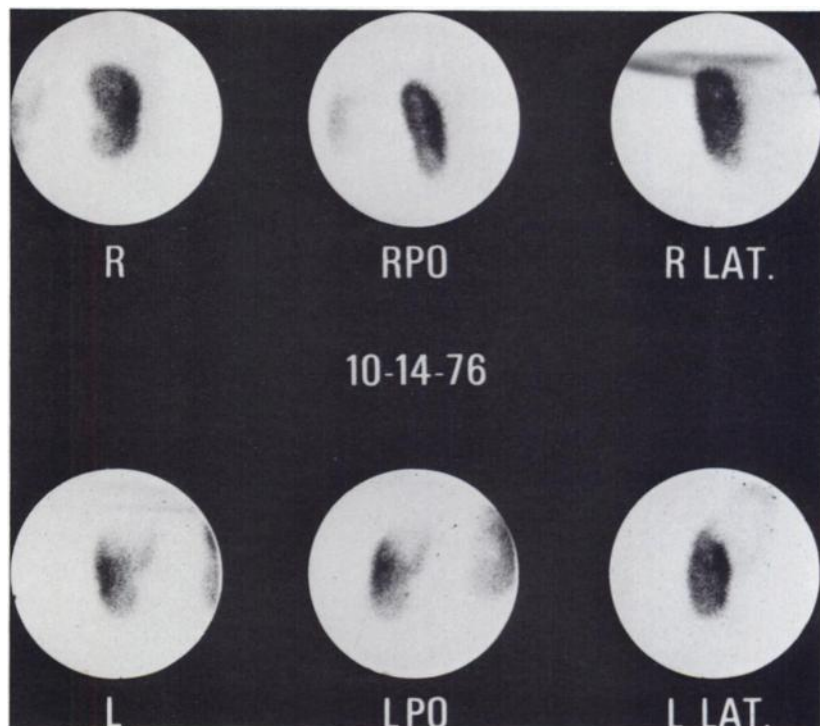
Gluceptate scintigram of patient in Fig. 3, with lucent zones in right kidney corresponding to calyceal system and large mass lesion in left upper pole.
